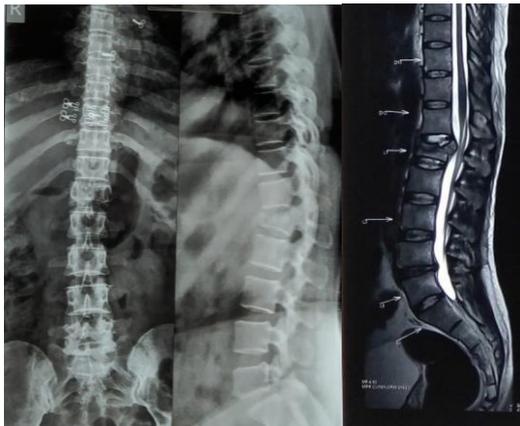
Pre op X-ray and MRI.
